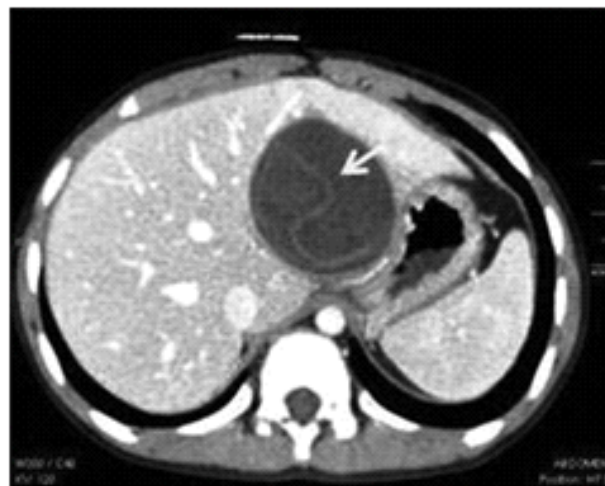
CT Scan image (News-Medical.Net)
